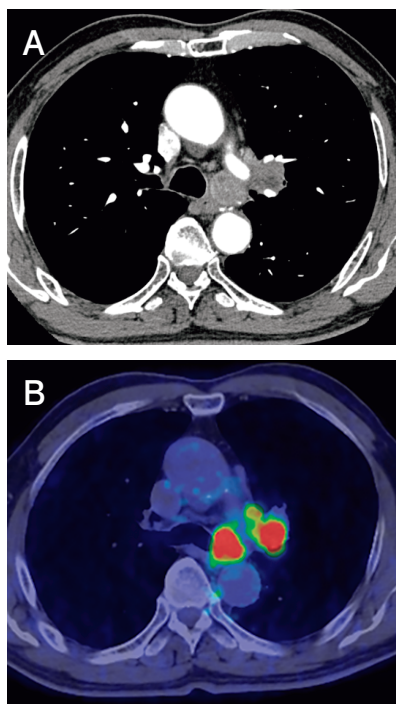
Image analyses before induction chemoradiotherapy. (A) A CT scan of the chest. (B) A PET-CT scan. A lung tumor invading the pulmonary artery with a swollen left lower paratracheal lymph node is visible (strong uptake of ^{18}F -fluorodeoxyglucose).
